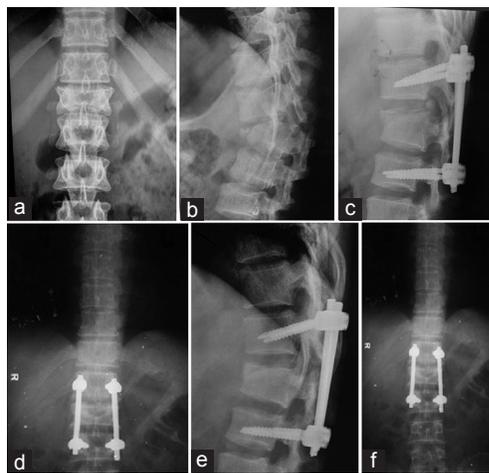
(a) Anterior-posterior radiograph of lumbar spine showing fracture of lumbar 1 vertebrae showing compression fracture, (b) lateral radiograph of lumbar spine showing fracture of lumbar 1 vertebrae showing compression fracture, (c) anterior-posterior radiographic view at post-operative day 1 of lumbar spine showing implant fixation in D12 and L2 vertebrae and deformity correction, (d) lateral view radiographic view at post-operative day 1 showing implant fixation in D12 and L2 vertebrae and deformity correction, (e) lateral view of same fracture at 41 months of follow-up showing fracture union, (f) anterior posterior radiographic view of same fracture at 41 months of follow-up.
